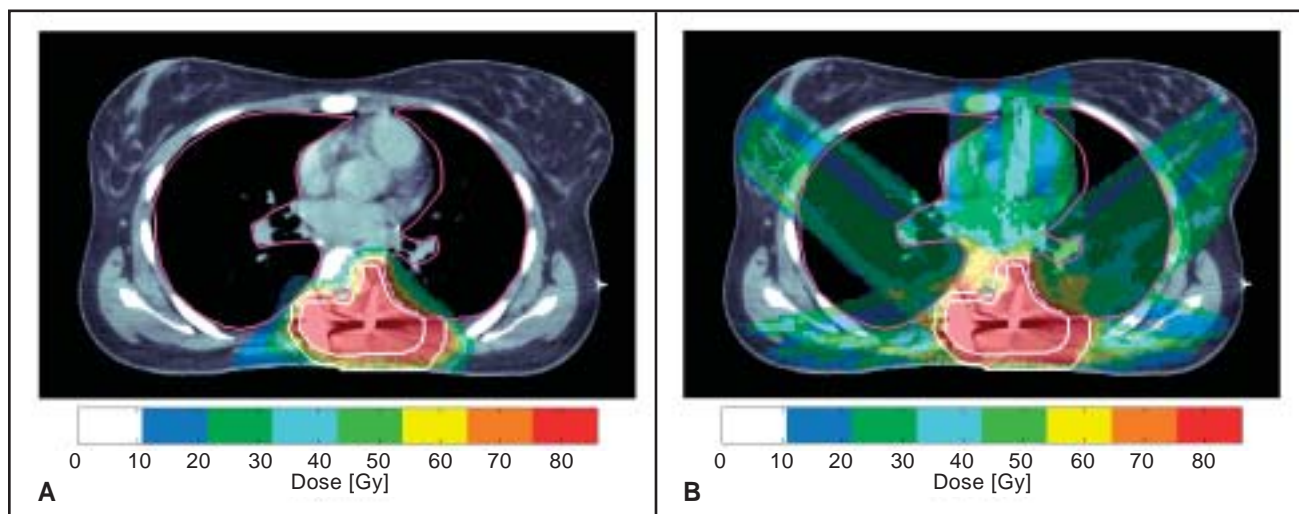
Dose distribution for intensity-modulated protons (A) or intensity-modulated photons (B) in a transverse plane (computed tomography slice) through the center of the tumor in a patient with a thoracic paraspinal sarcoma. The isodose contours are represented by different colors (corresponding values in CGE are displayed below the figure). Note the significant reduction in lung and cardiac dose with intensity-modulated protons. From Weber DC, Trofimov AV, DeLaney TF, et al. A treatment planning comparison of intensity modulated photon and proton therapy for paraspinal sarcomas. *Int J Radiat Oncol Biol Phys.* 2004;58:1596-1606. Reprinted with permission from Elsevier.
